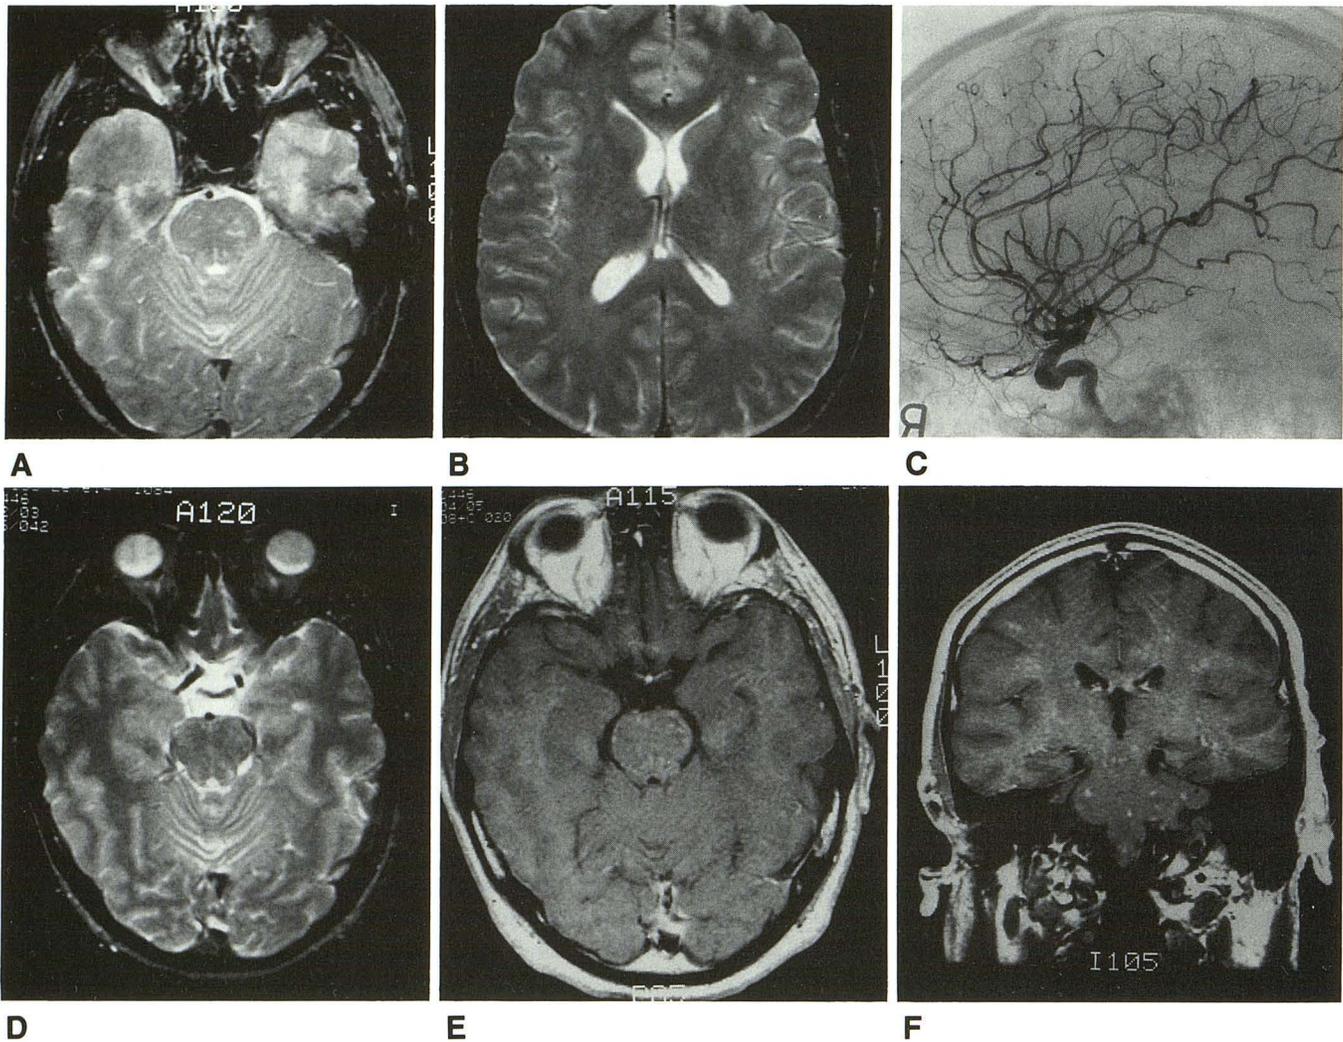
A, Axial T2-weighted (2800/90/1 [repetition time/echo time/excitations]) image from first study shows focal areas of hyperintensity in the brain stem.
